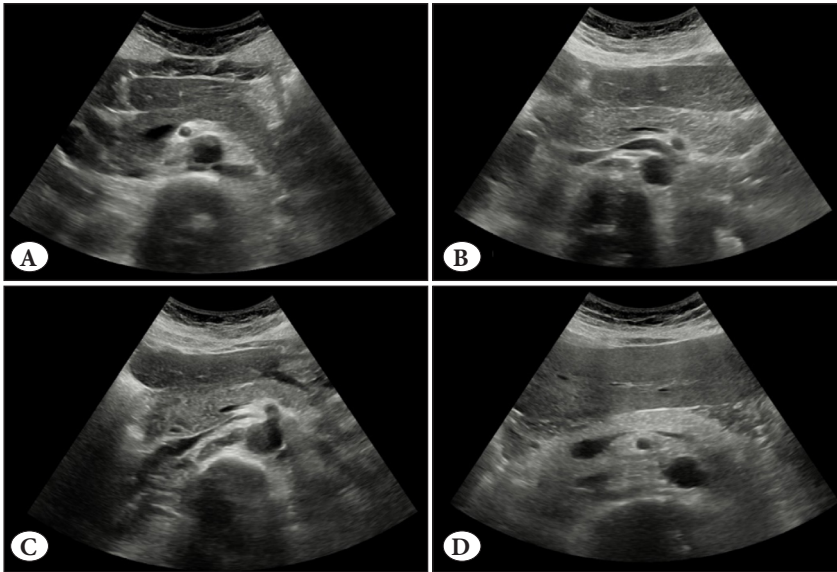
Ultrasonographic findings of NAFPD
